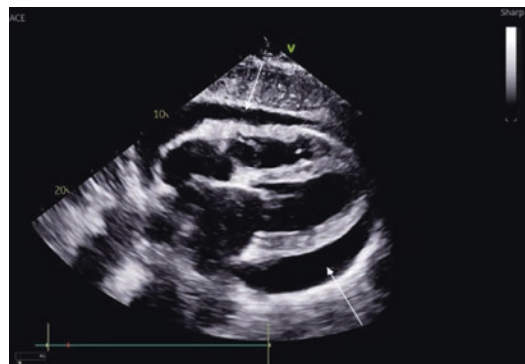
Pericardial effusion on echocardiography. White arrows point to large circumferential pericardial effusion
